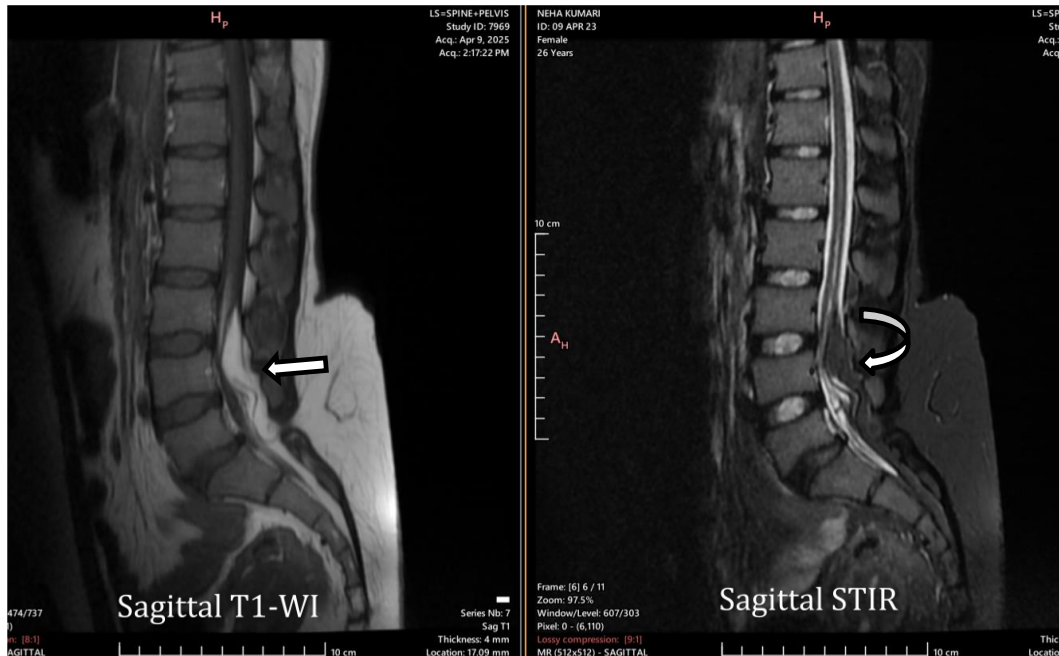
Sagittal T1-weighted and Sagittal STIR MRI
